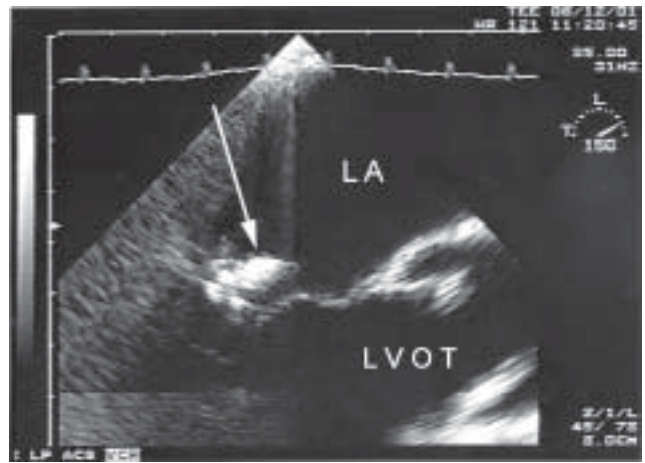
Still figure from transesophageal echocardiogram in systole. The vegetation is seen as a large echo-dense mass on the mitral leaflet (arrow). Left atrium (LA) and left ventricular outflow tract (LVOT).
